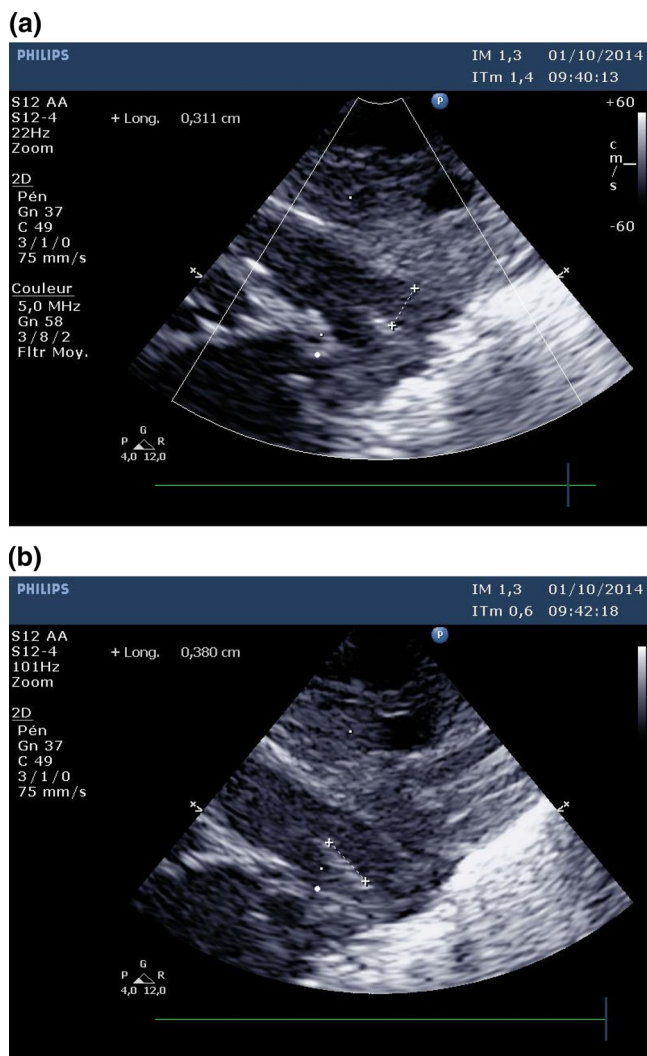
2D echocardiographic measurement of PDA (a) diameter and (b) length [Color figure can be viewed at wileyonlinelibrary.com]
